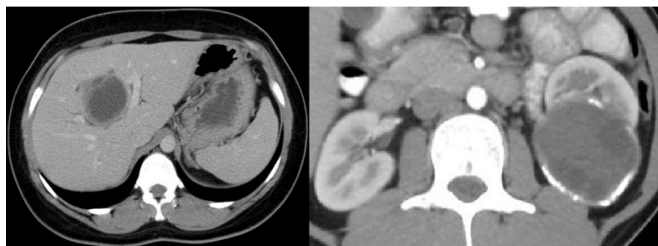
CT of Abdomen showing hydatid cyst of liver AND left renal hydatid cyst.
